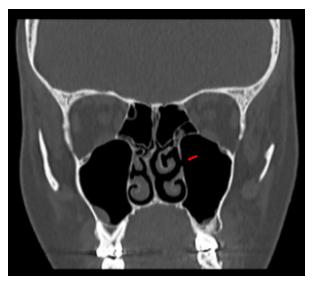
Preoperative sagittal view computed tomography image of nasal sinuses, red arrow pointing towards the left sided accessory maxillary ostia in the left posterior nasal fontanelle
